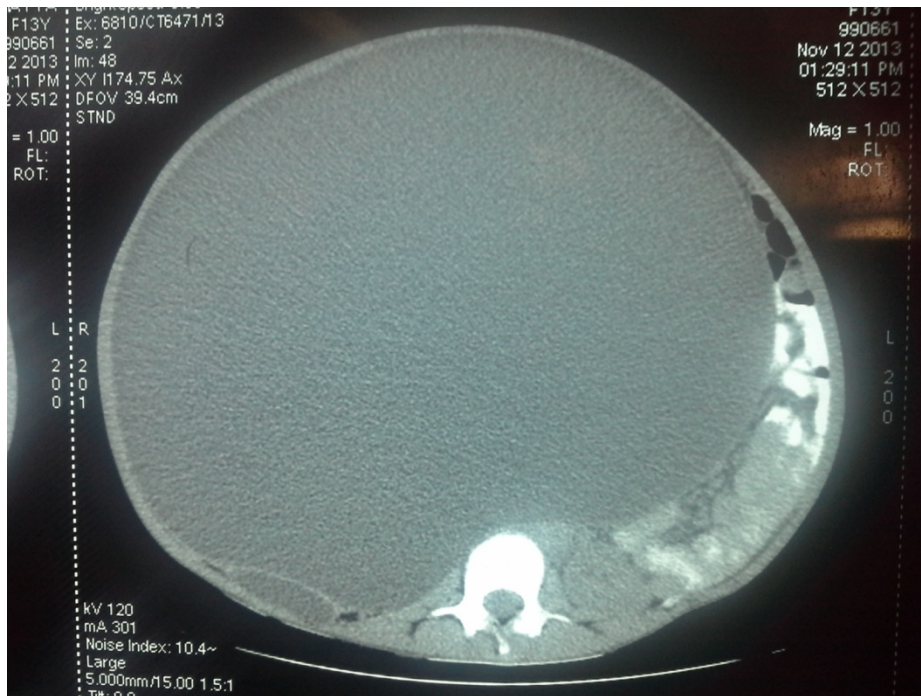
CT Scan Showing huge cystic mass displacing the entire abdominal contents to the left
